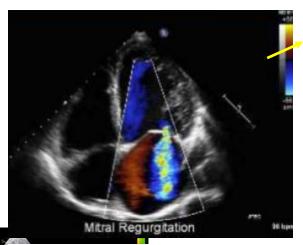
Example of an apical 4-chamber view (left: focus on the left ventricle; right: focus on the left atrium)
